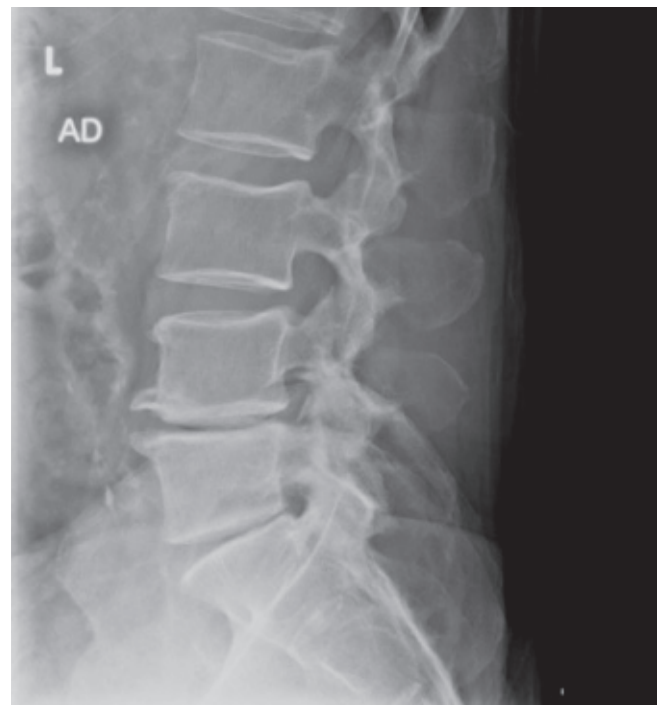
Plain radiograph, lateral view of lumbar spine, of 72-year-old male with severe degenerative disk disease at L4-5 and L5-S1.
